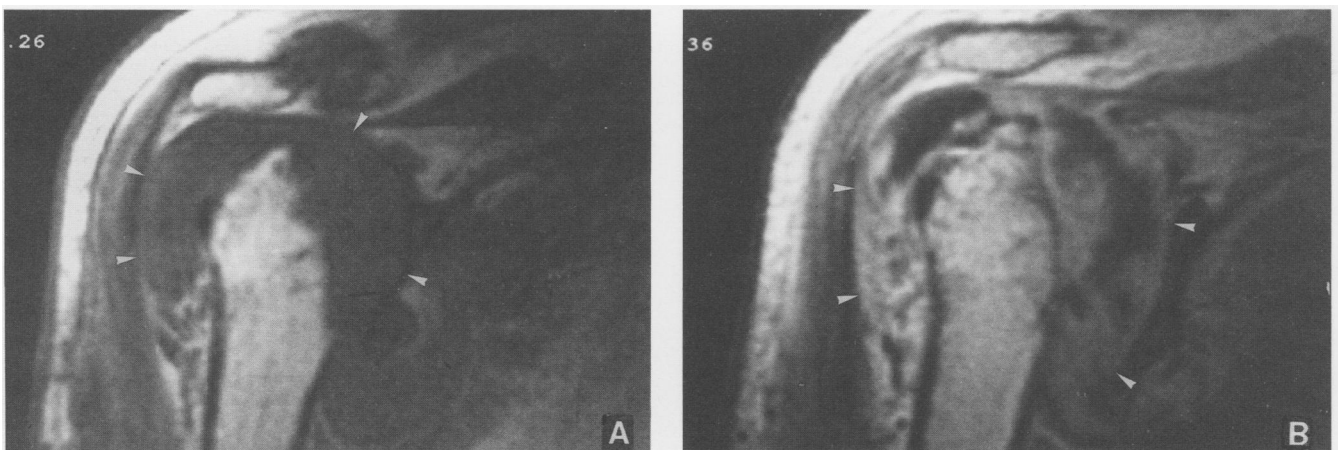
Coronal MRI through the mid-remnant humeral head. A: T1 weighted image showing that the glenohumeral and subdeltoid spaces contain a largely isointense mass (arrowheads), with small hypointense areas within. B: Post-gadolinium DTPA T1 weighted image showing marked contrast enhancement, mainly located peripherally, indicating active inflammatory tissue (arrowheads).
